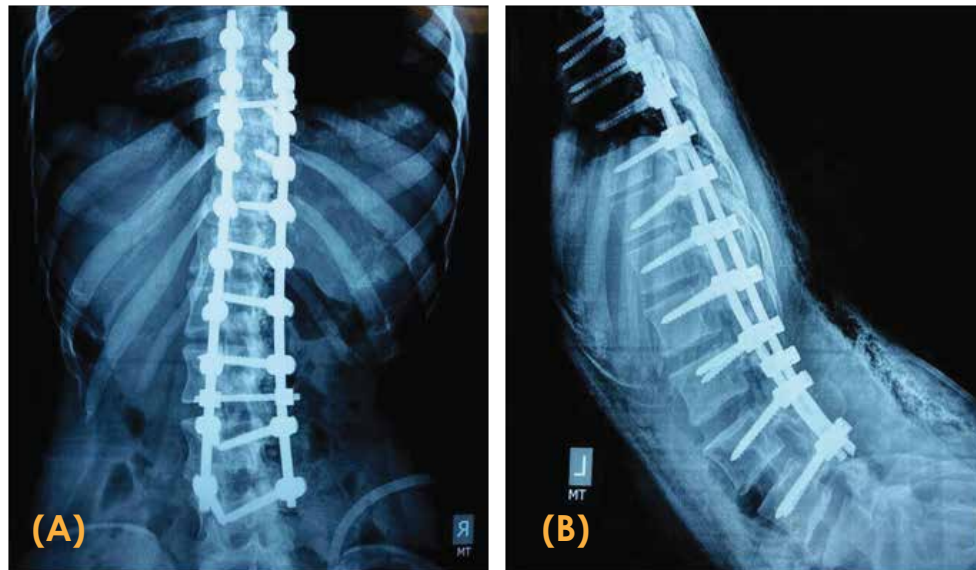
Post-operative x-rays of a female patient aged 13, with AIS having a Cobb's angle of 62 degrees corrected using pedicle screws segmental fixation. (A) Antero-Posterior View (B) Lateral View
